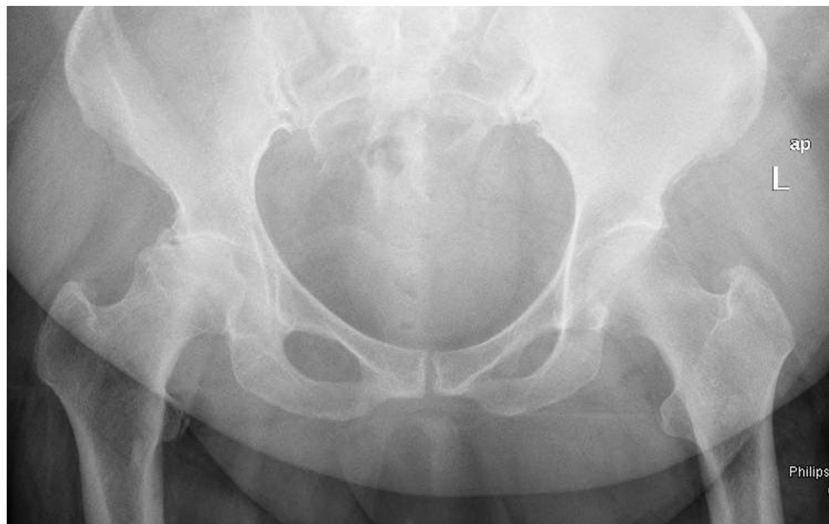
Case 2; Anteroposterior pelvis radiograph demonstrating right hip osteoarthritis.
